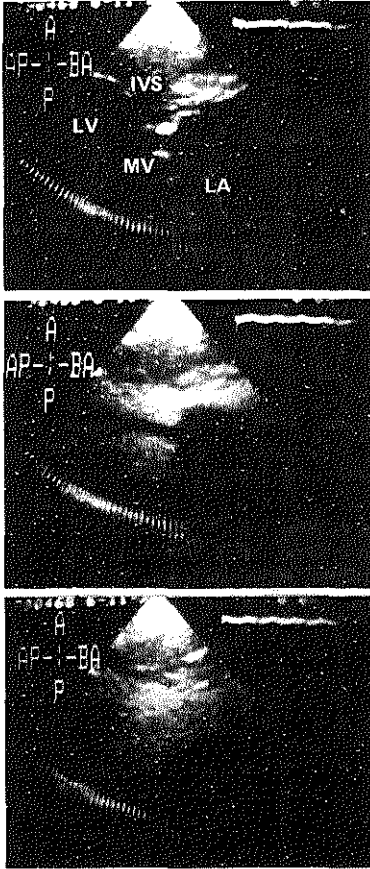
Stop-frame photographs of parasternal long-axis views of a patient with mitral valve stenosis before (upper panel) and after injection of echo contrast via a catheter in the left ventricle. The middle panel shows a frame recorded during diastole. The negative shadow caused by the non contrast blood flowing from the left atrium into the ventricle visualizes the transmitral blood flow pattern. During systole (lower panel), the echo contrast does not pass into the left atrium, excluding mitral incompetence.
